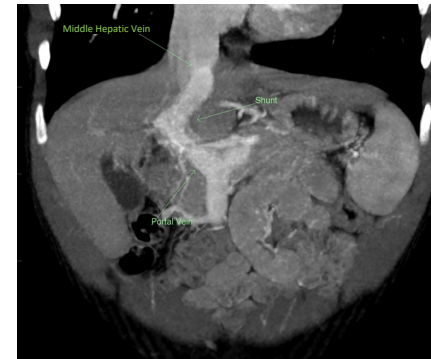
Abdominal CT angiogram demonstrating intrahepatic portosystemic shunt (IHPSS) between the portal vein and middle hepatic vein.
